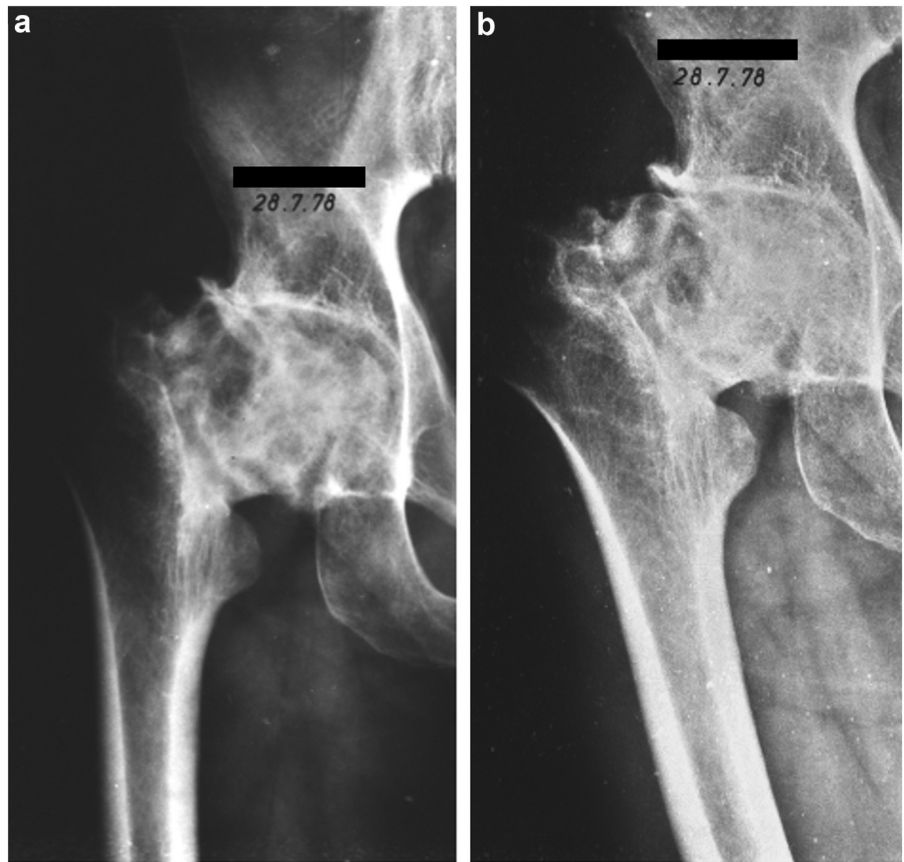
Anteroposterior (a) and lateral (b) radiographs demonstrating a collapsed femoral head with an altered contour and varus deformity.
